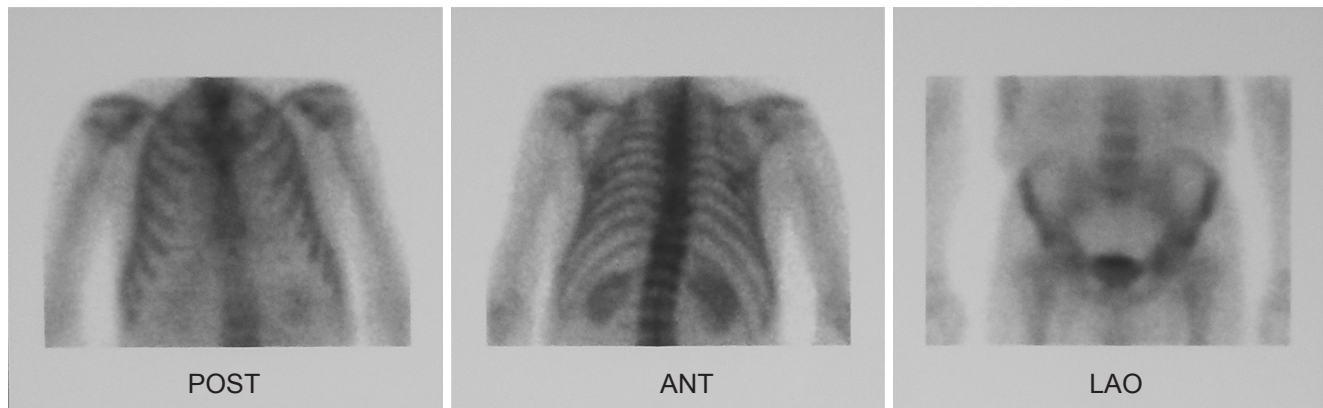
99m Technetium helix destabilizing protein scintigraphy post sorafenib, immunosuppression modification and radiation, showing regression of metastatic lesions in the spine and ribs. POST: posterior; ANT: anterior; LAO: left anterior oblique
